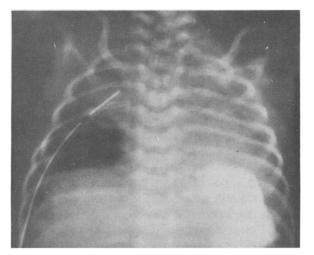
(Case 1) Postoperative radiograph of the chest made following right diaphragmatic plication. There is failure of expansion of the hypoplastic right lung.
